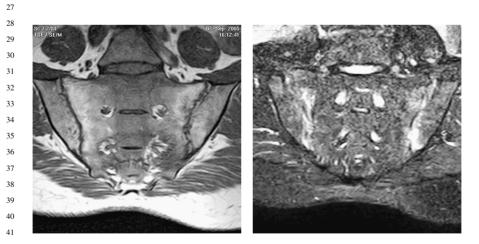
Sacroilitis of ankylosing spondylitis. MRI (axial T1W and STIR) images of a HLA B27+ve
